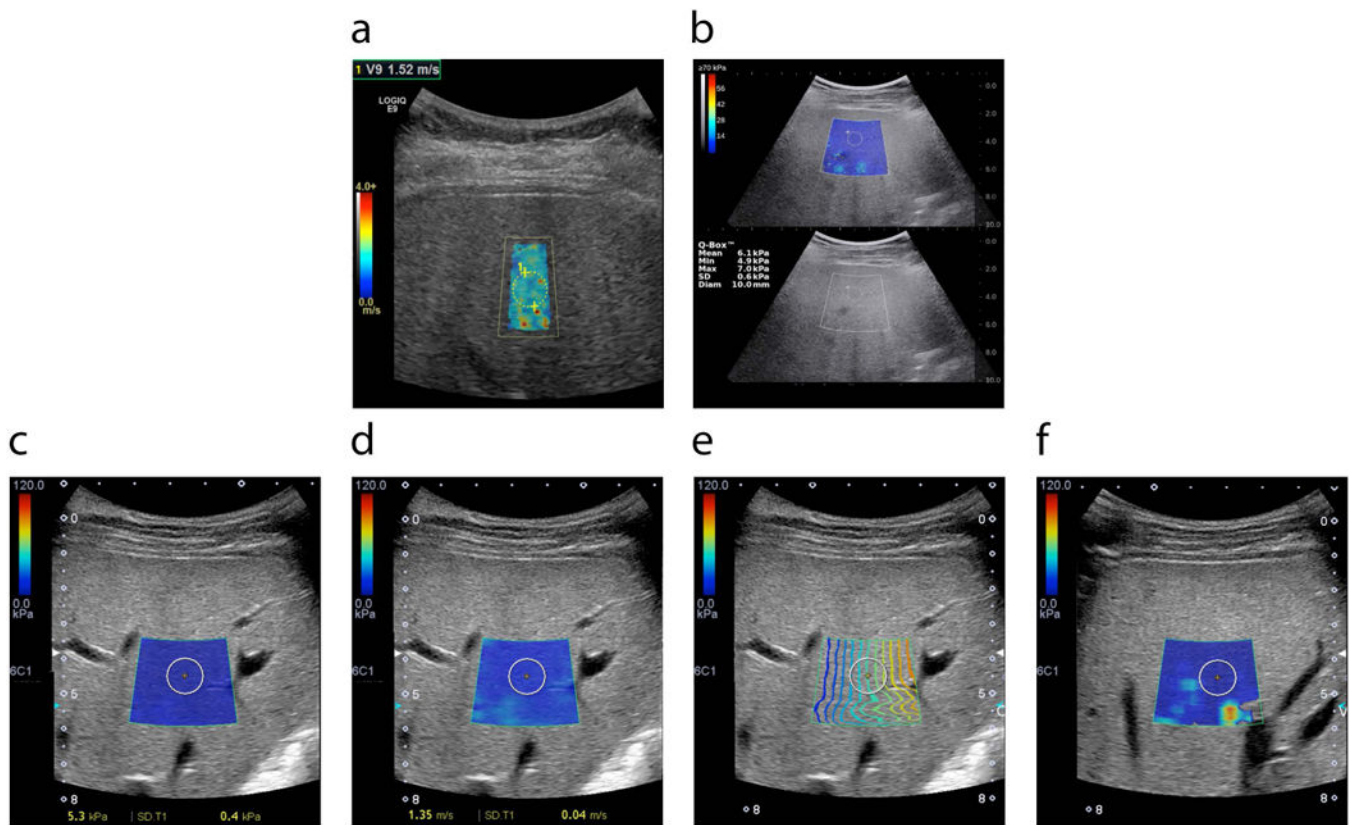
2D-SWE technology is available in multiple devices manufactured by various vendors. Common features are colored polygonal elastogram maps and circular ROIs. The user selects the location of the elastogram away from overlying vessels and rib shadows and then places an ROI within a representative portion of the elastogram as described below. Mean stiffness or SWS values from the ROIs are reported. a) General Electric LOGIQ E9 ultrasound device. b) Supersonic Aixplorer ultrasound device. Stiffness value in kPa is presented at left corner of the image. Standard gray scale image is used as a guide. Tissue stiffness (c) or shear wave speed (d) can be presented in the same scanning session using the same device; images from Toshiba APLIO500 are presented as examples. Manufacturers add new software into the systems to increase the accuracy of the SWE results and decrease variability. For example, Toshiba system calculates the e) Contour map, f) Variance map. Based on the manufacturer's suggestions in contour map (e), operator located ROI in an area where propagation lines (colored lines) are parallel to each other. In variance map (f), operator located ROI in an area away from 'extreme' areas (yellow/red).
